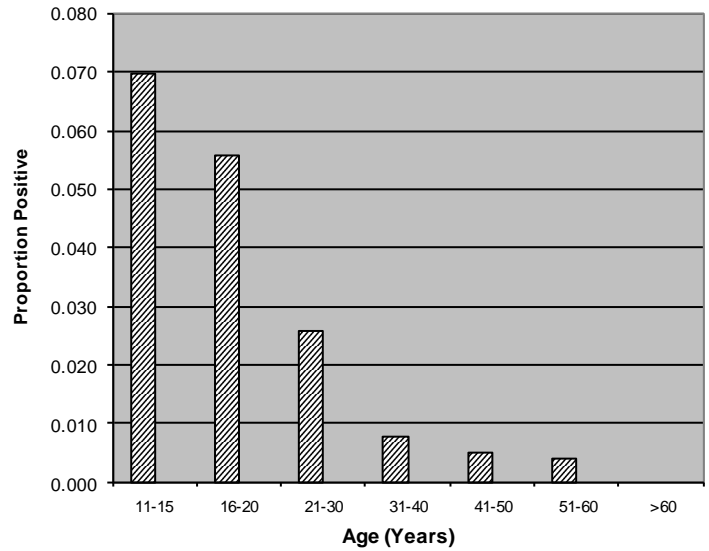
Proportion of Women with Positive Genital CT Tests - CLS 2001-02
